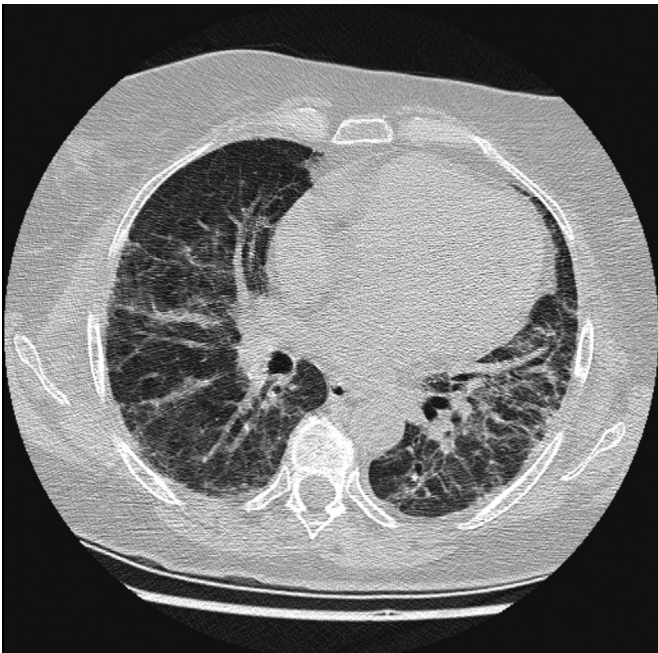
High-resolution computed tomography of the chest showing diffuse interstitial pneumonitis.
